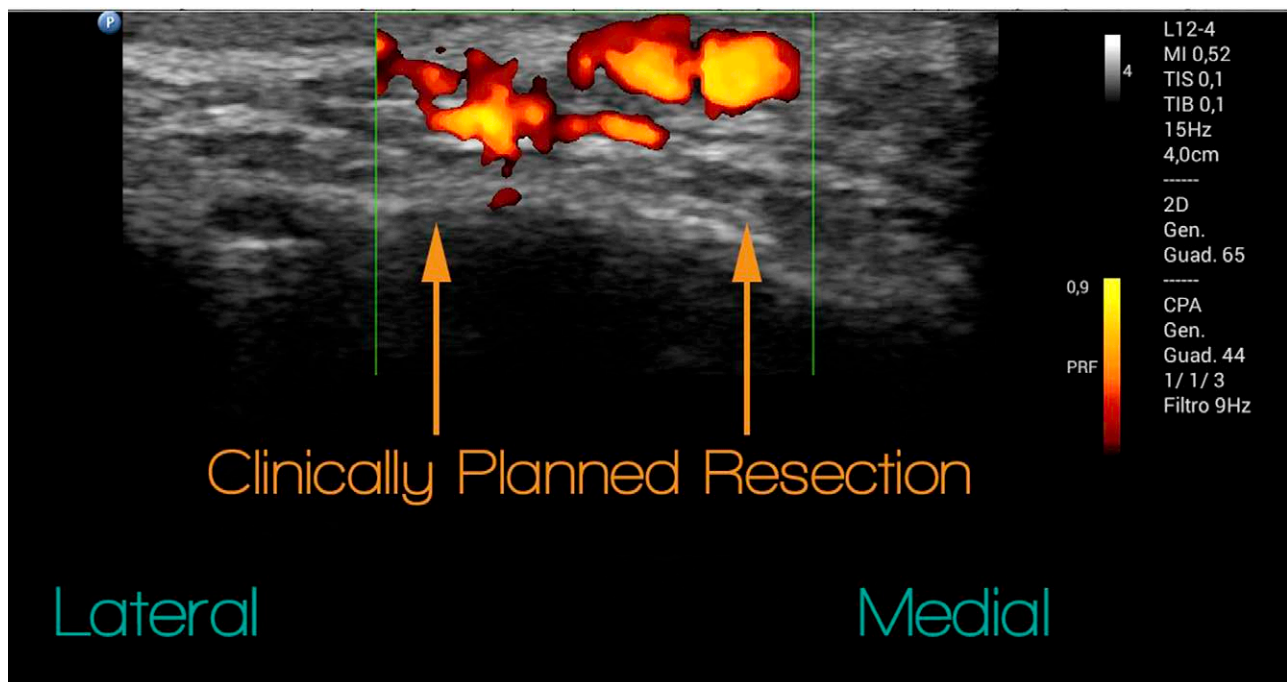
CDUS of the clinically planned resection. The AVM appears to involve the margins (orange arrows and green lines). AVM indicates arteriovenous malformation; CDUS, Color Doppler Ultrasound.
